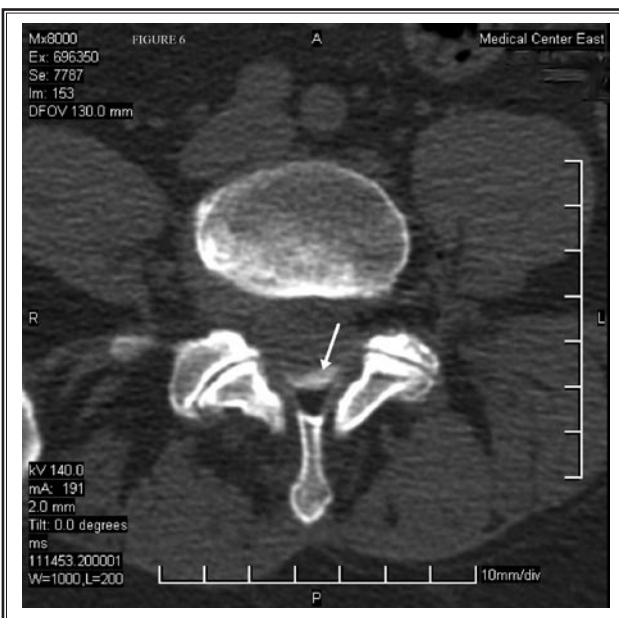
Axial CT demonstrating subdural spread within the posterior central spinal canal (white arrow).
